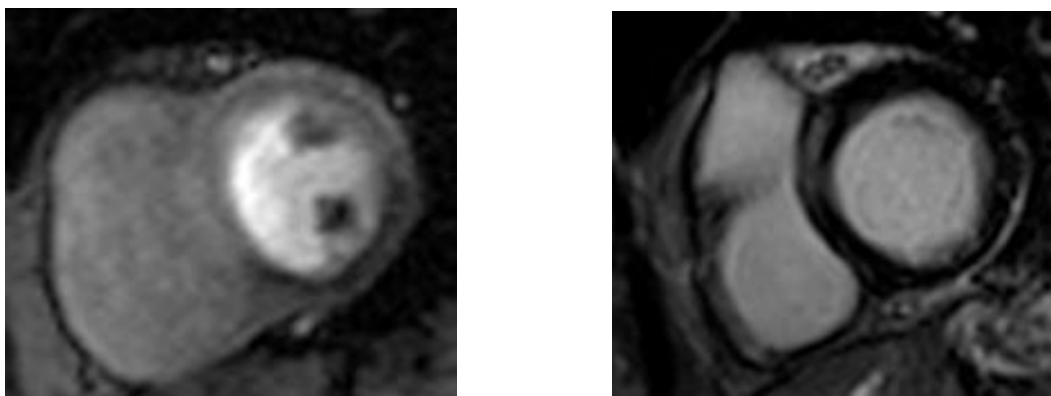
Examples of stress perfusion MRI pictures. Left: stress perfusion (stress induced ischemia in the inferior wall of the heart); Right: *LGE*.
